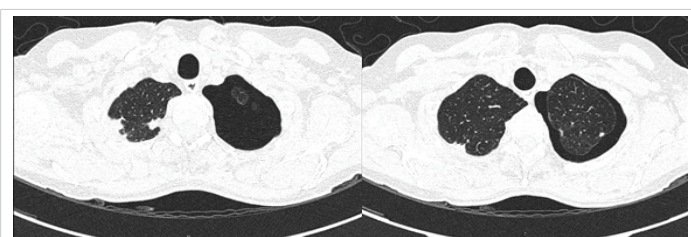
High-resolution computed tomography shows left pneumothorax in the superior lobe both images taken from the aging appointment.
